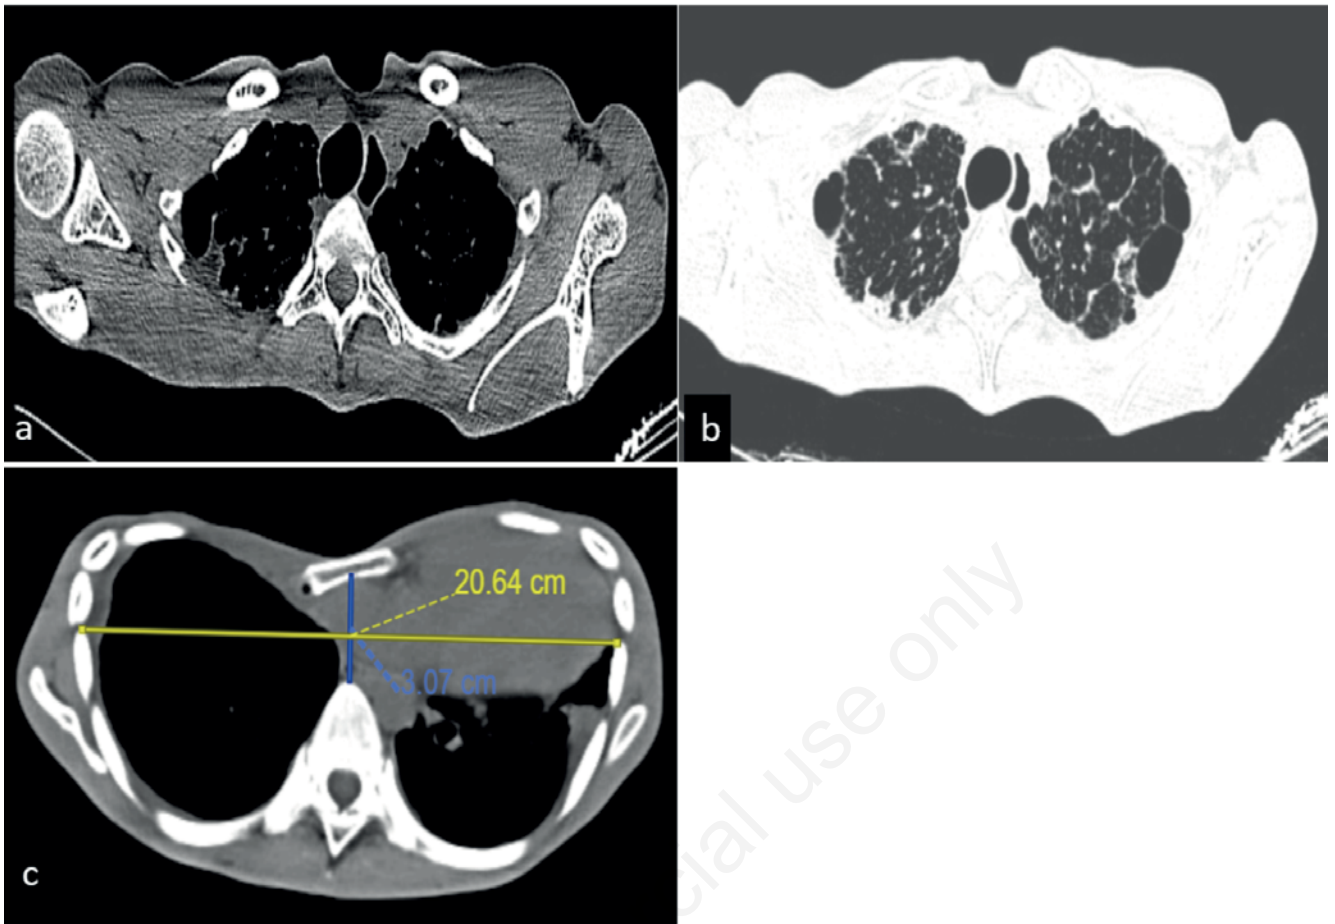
Transversal computed tomography of the chest. a) Bilateral pleural thickening; b) bilateral upper lobe bullous changes with interlobular septal thickening; c) severe pectus excavatum with Haller index of 6.7.
